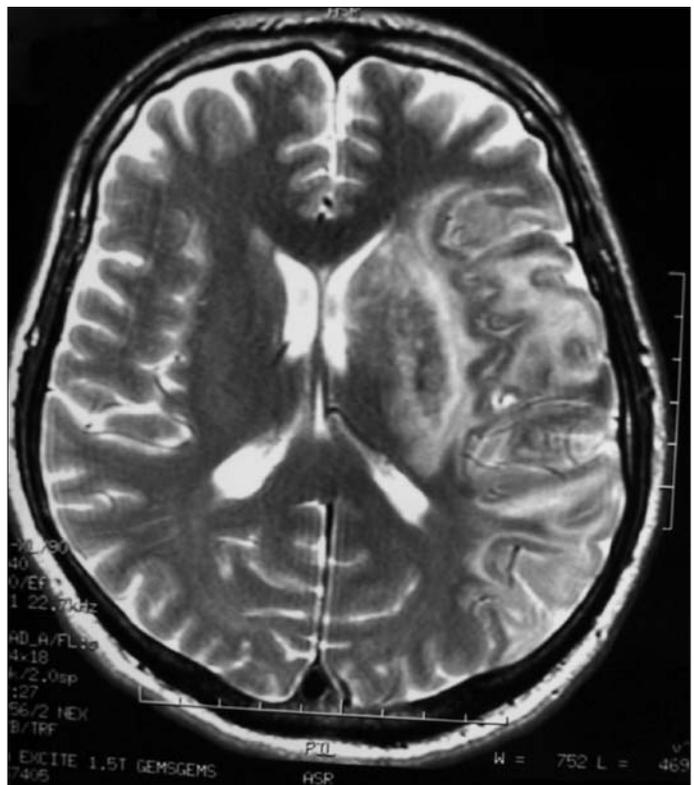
T2-weighted magnetic resonance imaging demonstrating infarction due to left middle cerebral artery occlusion.
